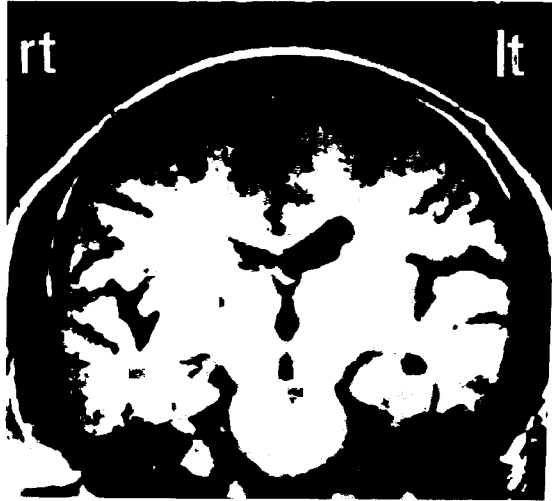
Brain MRI (T1-weighted image) in Patient 1 showing atrophy of the left inferior temporal gyrus and the adjacent fusiform gyrus
